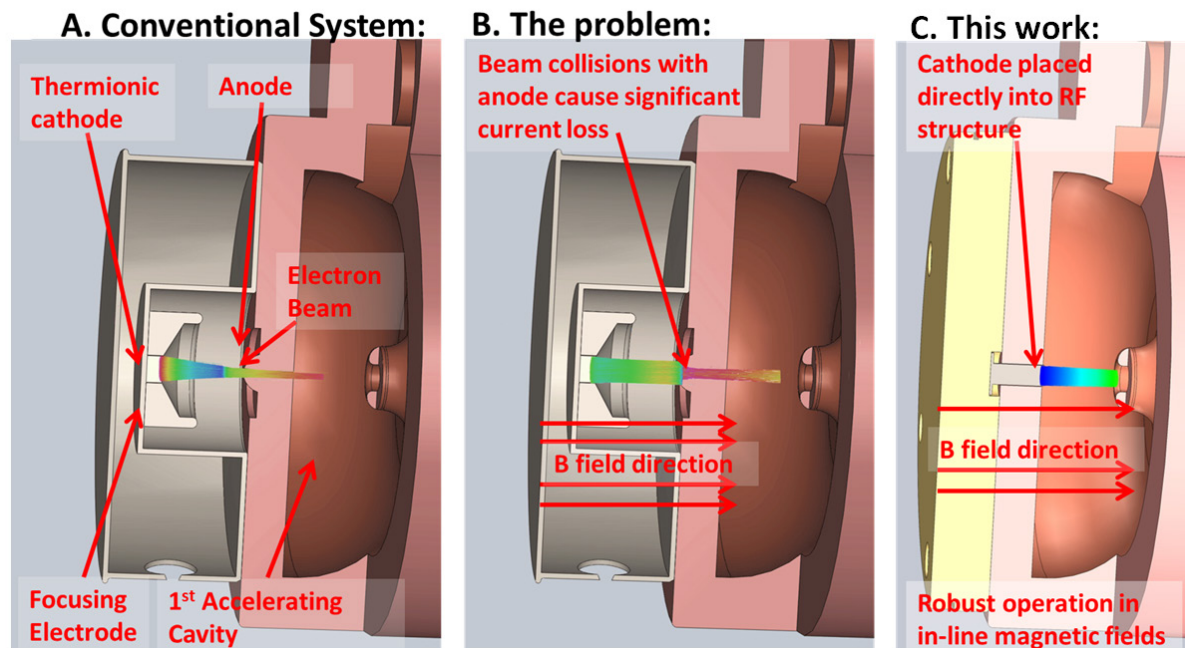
A) conventional medical electron accelerator utilizing a steady state stream of electrons, however B) performance is compromised in in-line MRI-Linac systems. C) In this work we are proposing a novel electron accelerator utilizing an RF electron source which is robust to operation in magnetic fields.
